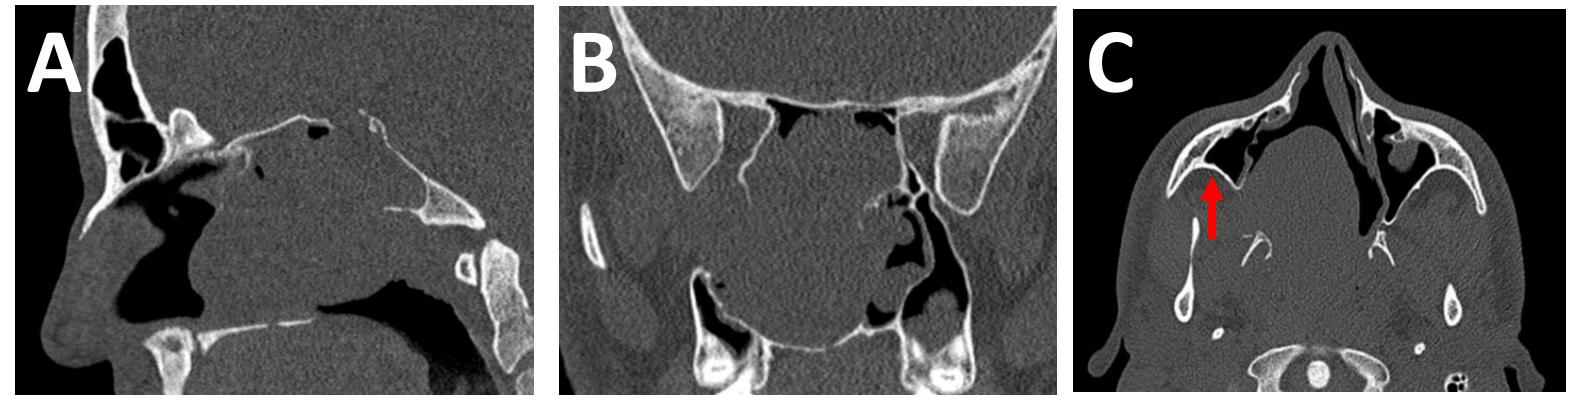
(A) Sagittal, (B) coronal, and (C) axial cuts from a non-contrast CT sinus demonstrating tumor extension into the right pterygopalatine fossa and the classically described Holman-Miller sign (anterior displacement of the posterior maxillary sinus wall) as denoted by the red arrow.
